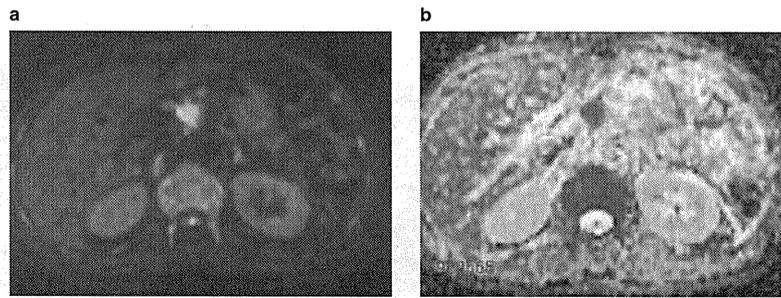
Pancreatic head cancer. (a) Diffusion-weighted magnetic resonance imaging showing a nodular high-intensity area ($b=800\text{ mm}^2/\text{s}$). (b) ADC map in the same patient. ADC, apparent diffusion coefficient.
